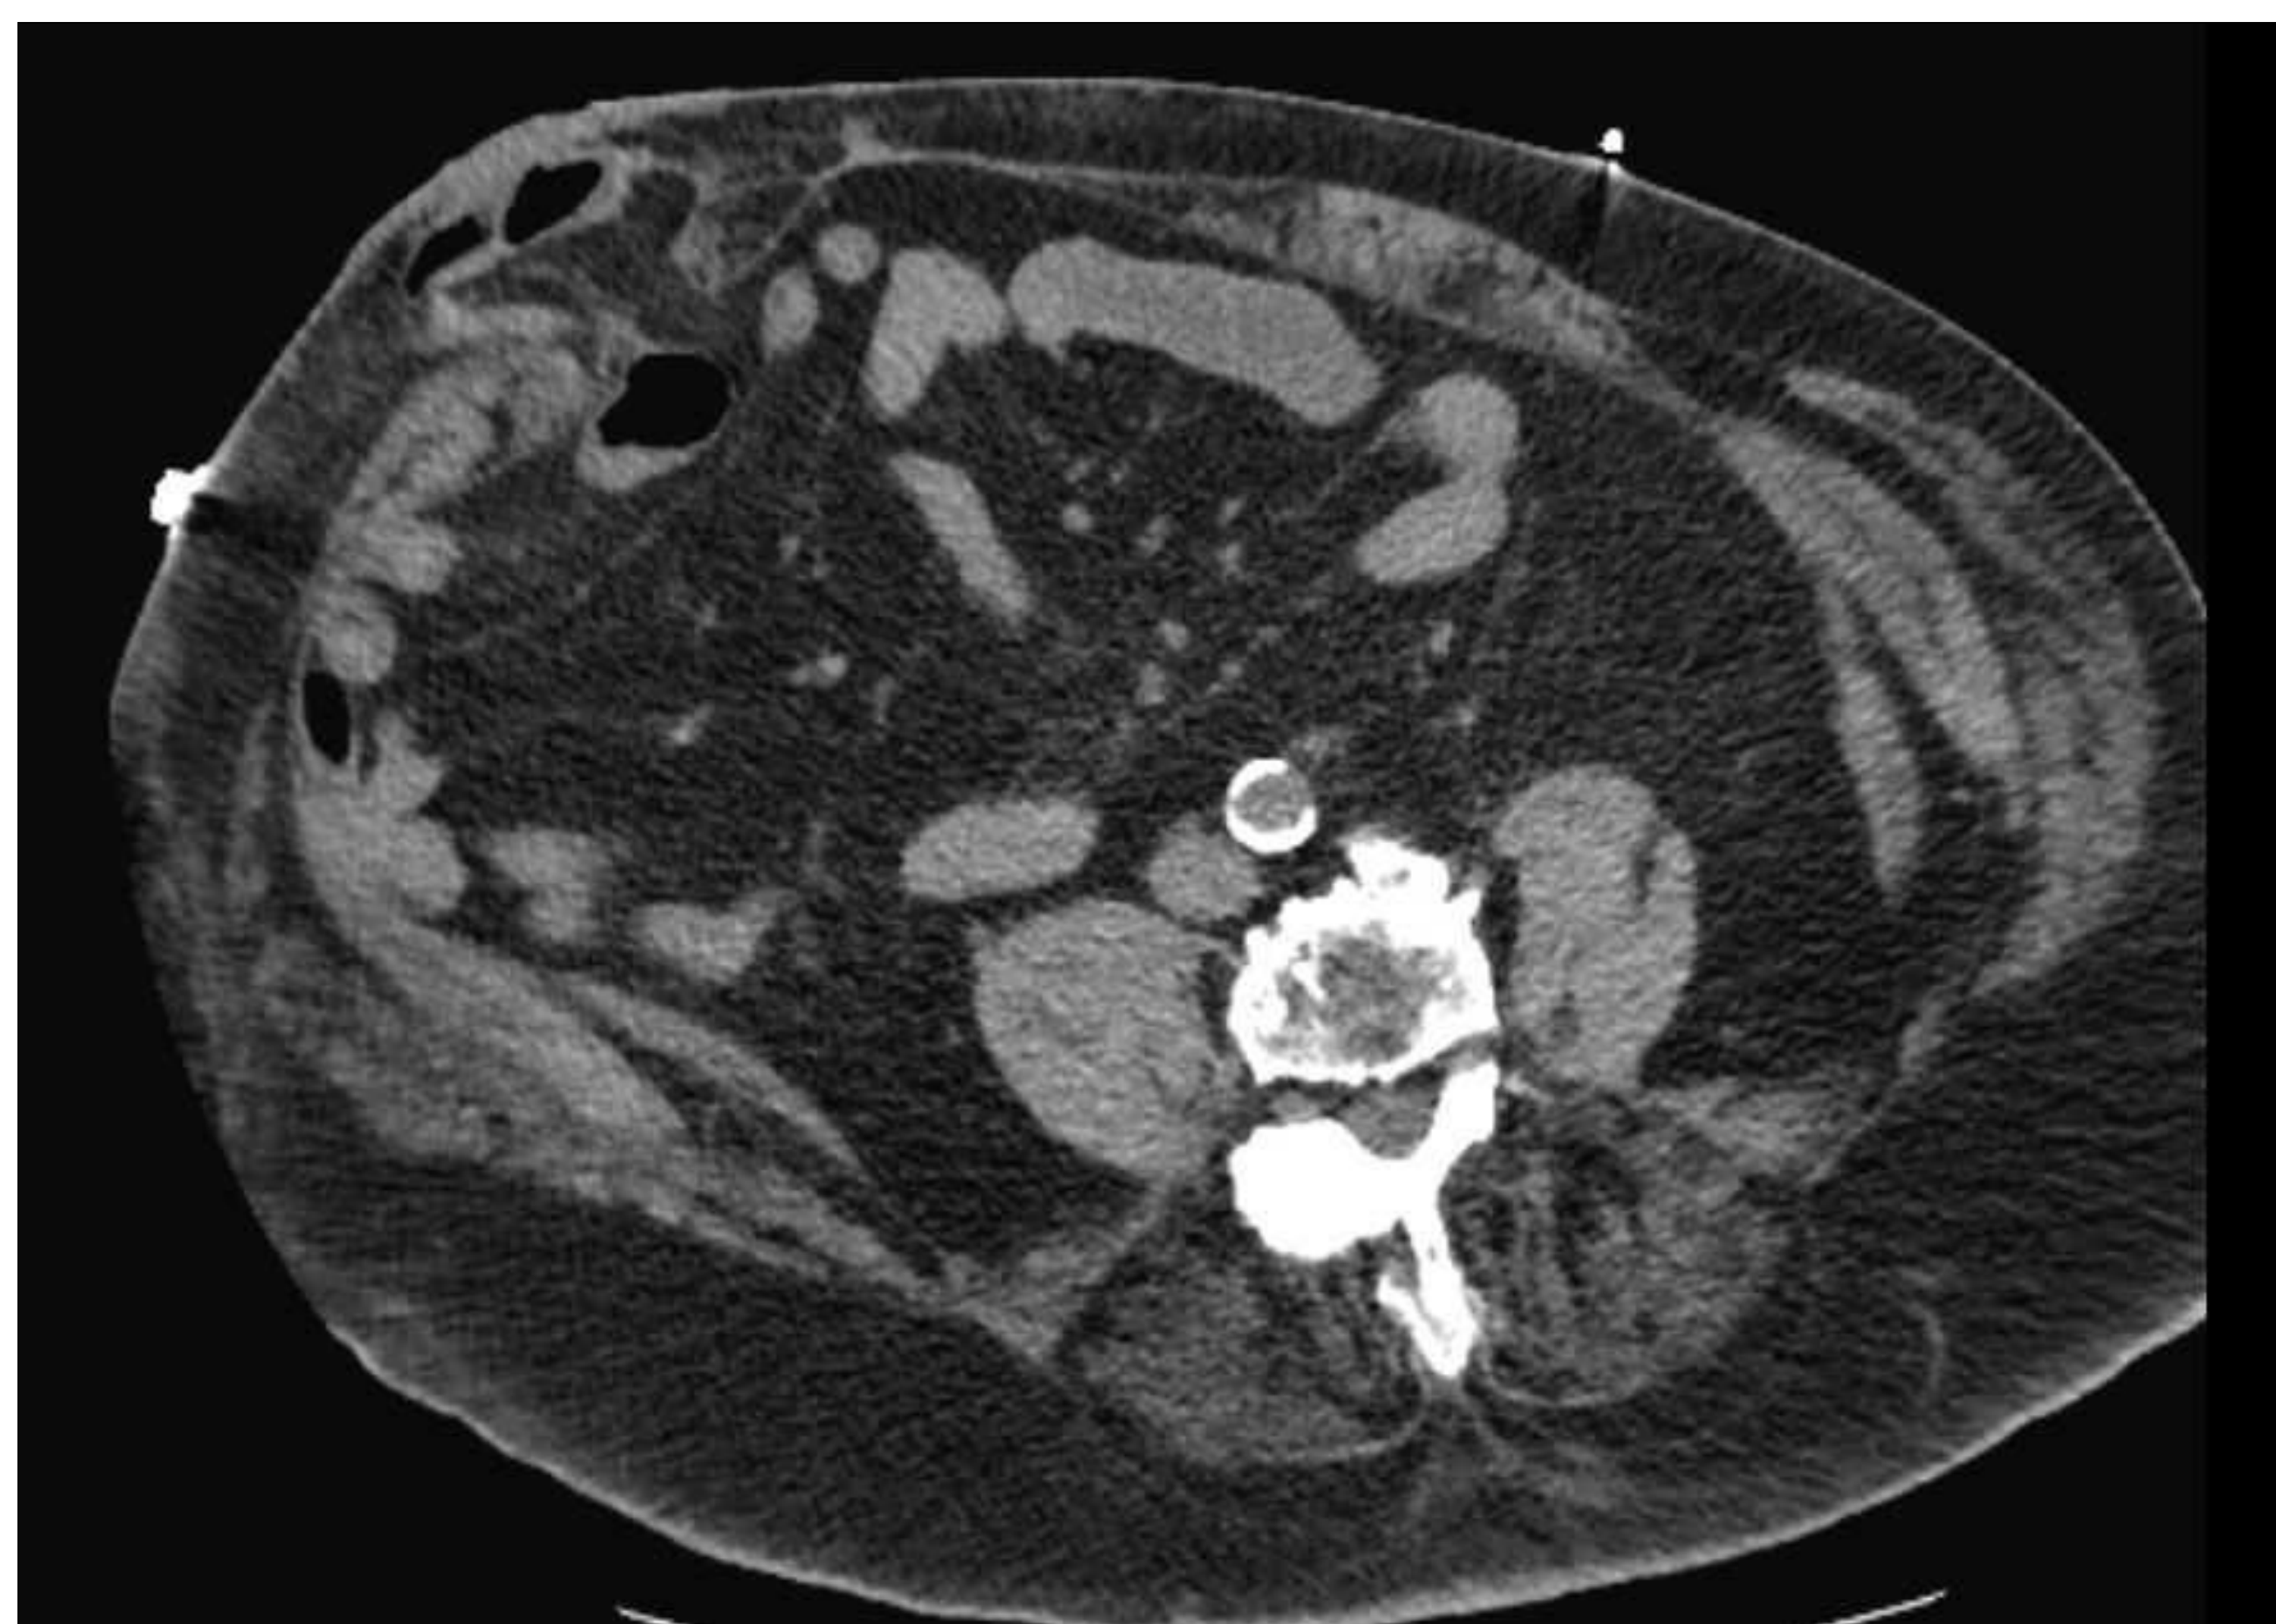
CTA showing single nonbleeding varix around ostomy site
